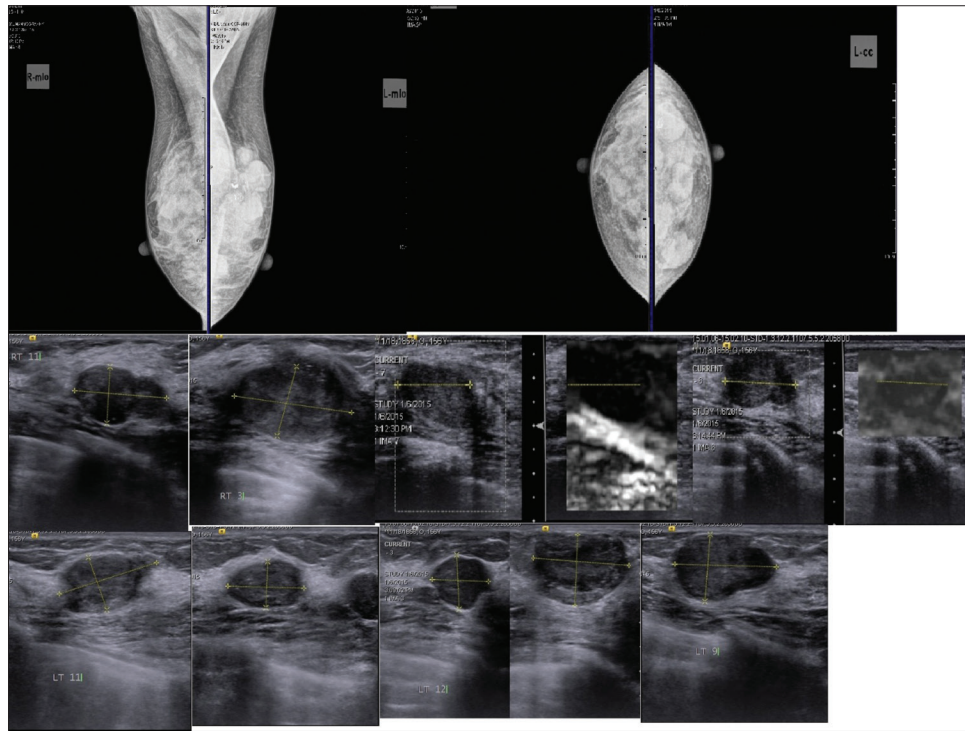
Mammography with multiple opacities in both breast sonography showed more number of sols in both breast, likely to be benign, presumed fibroadenomas
